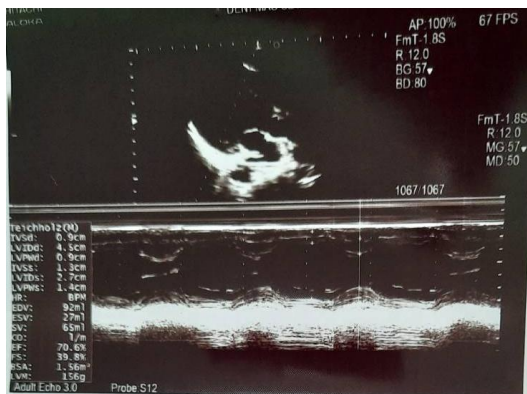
Echocardiography result
